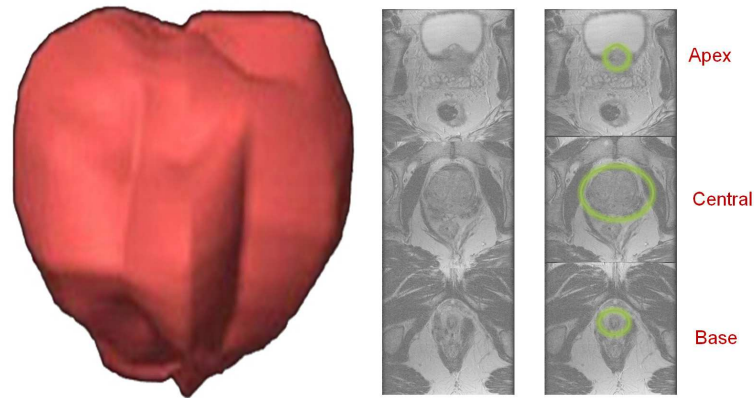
In MRI, the soft tissue contrast varies depending on the region of the prostate. Image in the center shows prostate in different region and image in the right shows corresponding segmentations.
